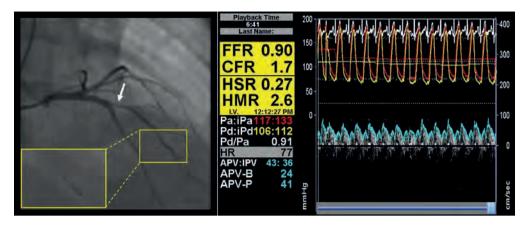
Coronary angiogram showing a visually intermediate stenosis (50%) in the first diagonal branch (white arrow). In addition, combined pressure and Doppler flow velocity recordings were acquired using a ComboWire* (Volcano Corp.) positioned distal to the stenosis. A stable Doppler flow signal was established by flipping the tip of the ComboWire, and obtaining the Doppler signal retrogradely.
